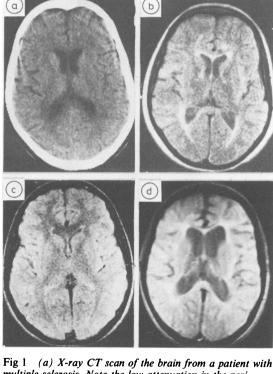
(a) X-ray CI scan of the brain from a patient with multiple sclerosis. Note the low attenuation in the periventricular white matter. (b) MRI scan (spin-echo sequence) of the same patient as in (a). The periventricular abnormalities are more extensive and an additional discrete lesion is visible in the right frontal lobe. The changes are more extensive posteriorly. (c) MRI scan from a healthy control subject. (d) MRI scan from a patient aged 53 with Binswanger's disease.
